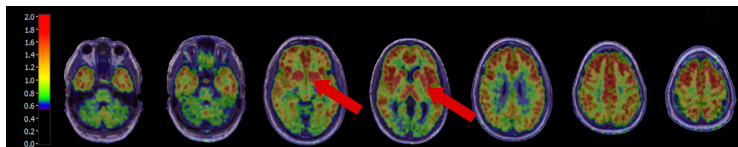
Spatial distribution of $[^{11}\text{C}]$ buprenorphine uptake (SUVr maps).
